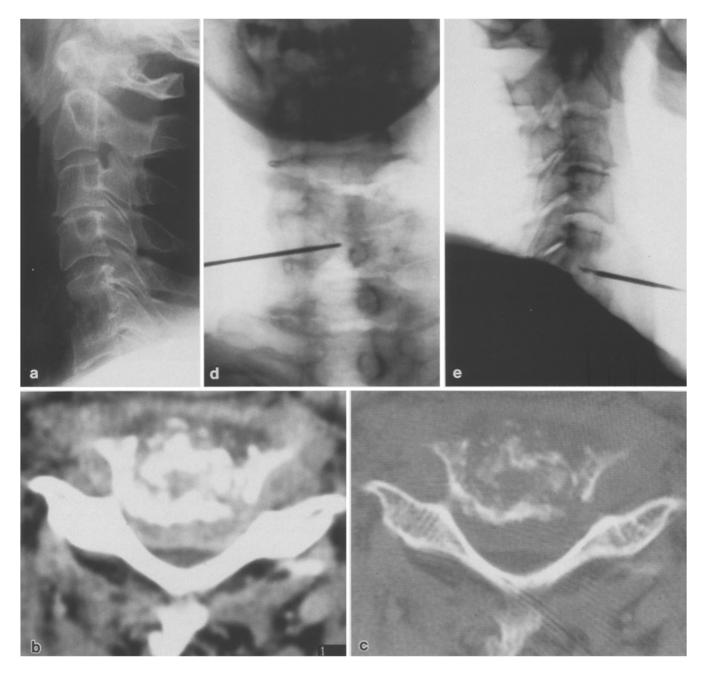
Case 7. The cervical spine examination (a) shows a rarefaction with loss of intervertebral height at C5–6 level. The contrast infused CT (b, c) confirms the lytic process and shows a soft tissue component extending in the paravertebral space and into the spinal canal. The PAB is carried out and the antero-posterior (d) and lateral views (e) show the exact position of the needle
